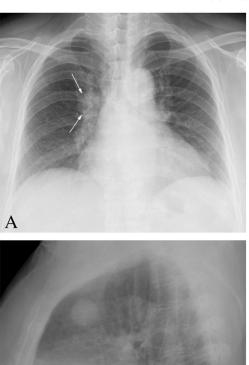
Chest radiographs of (A) posteroanterior (PA) and (B) lateral view. There is a well-demarcated large nodule in the right upper lobe, coalescent with a hilar opacity on the PA radiograph (arrows).
